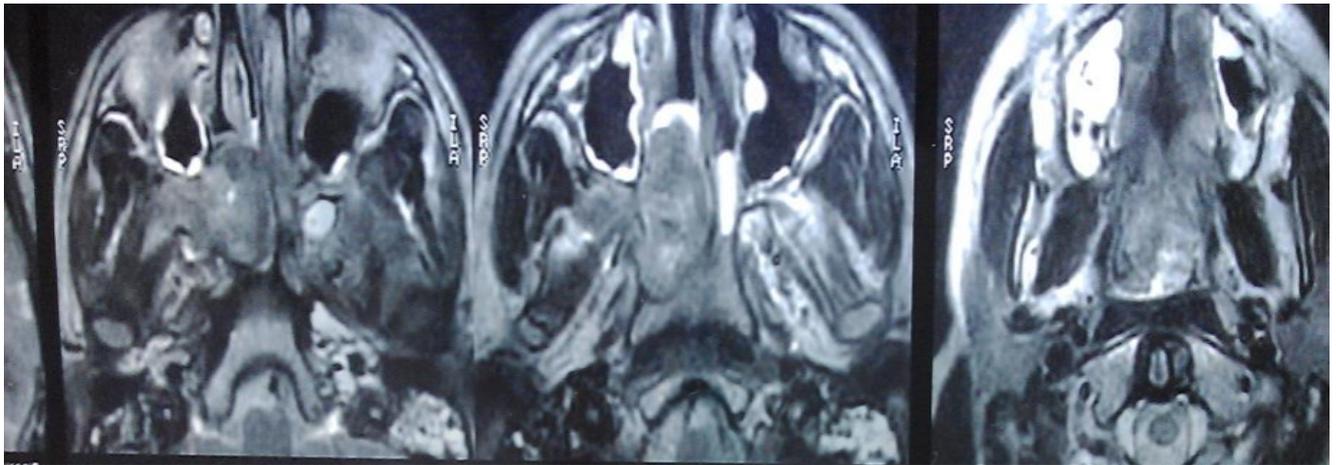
CT scan of patient F.A., nasopharyngeal tumor
